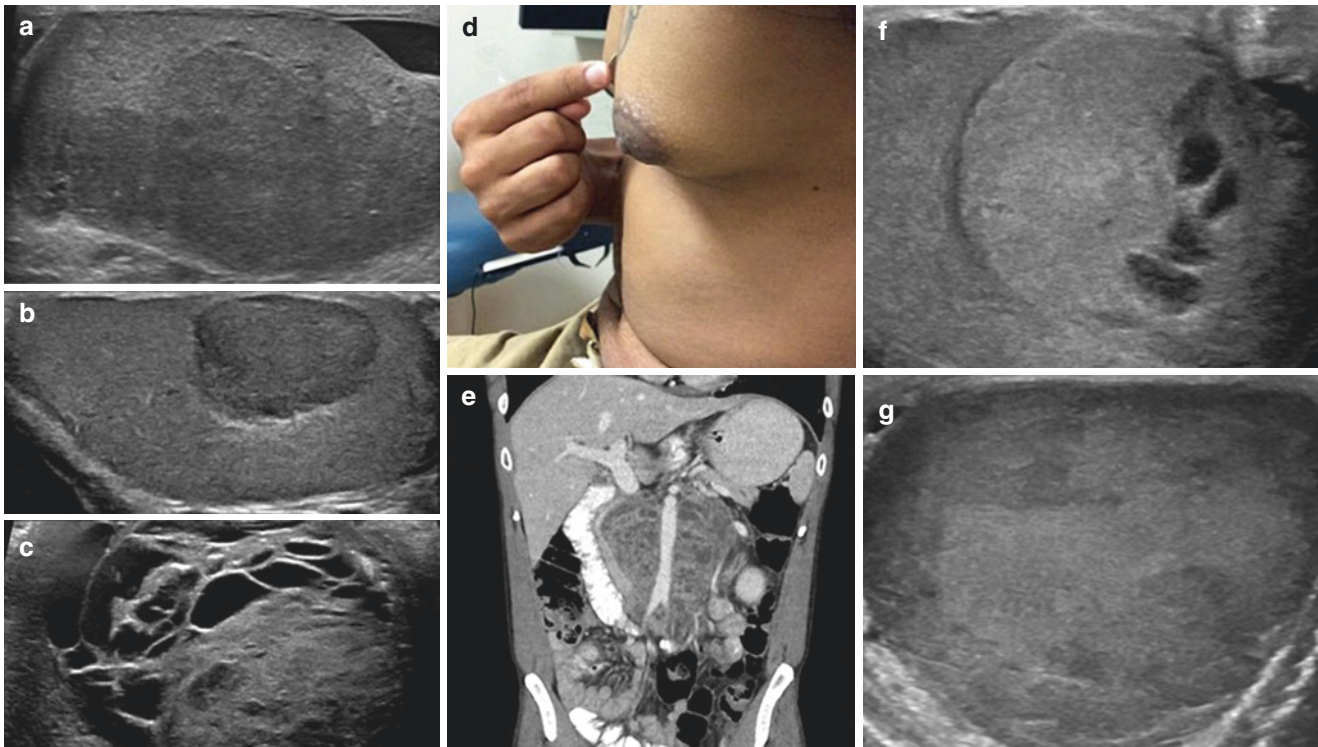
Testicular tumors. These patients presented initially with scrotal complaints, were imaged with a scrotal ultrasound, and ultimately underwent radical orchiectomy. (a) This poorly circumscribed hypoechoic mass was found to be lymphoma. (b) This well-circumscribed, small, and difficult-to-palpate lesion was found to be a Leydig cell tumor. (c) Some testicular tumors have significant hypoechoic areas consistent with cystic components—this finding is suggestive of teratoma, which comprised the majority of this patient's nonseminomatous germ cell tumor. (d) Gynecomastia is sometimes associated with testicular tumors. This can occur due to hormonal secretion from testicular stromal tumors (in this patient estradiol was being secreted by the Leydig cell tumor depicted in b). Gynecomastia can also occur due to elevated beta-HCG secreted by germ cell tumors. (e) This patient had increasing abdominal pain and leg swelling during
